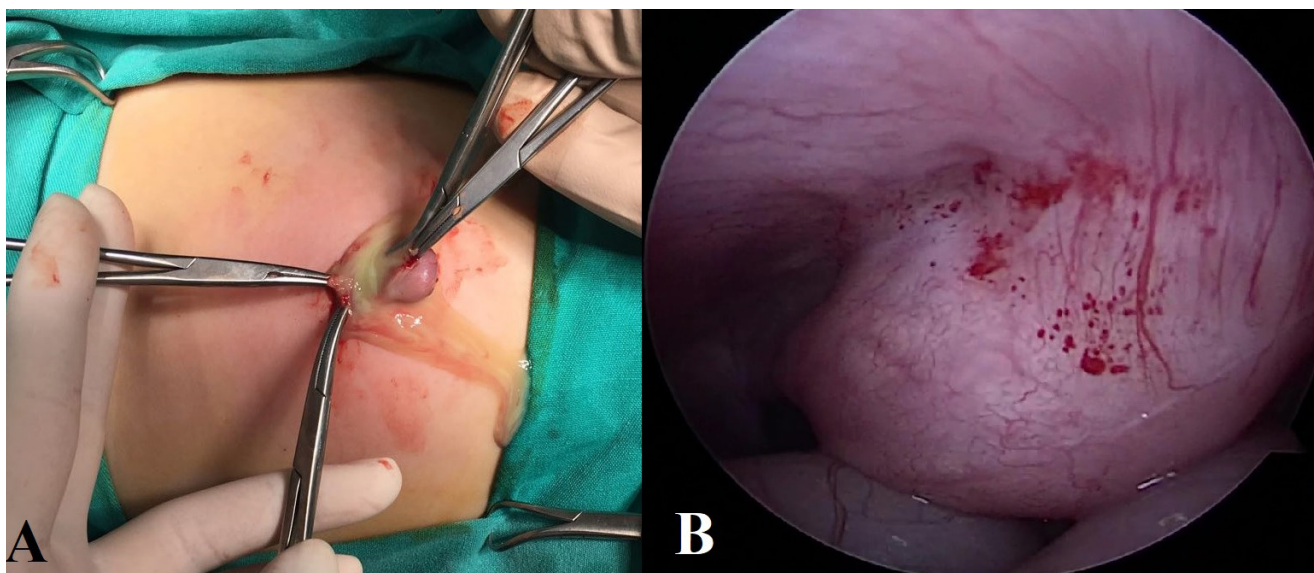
Discharge through the umbilicus in a patient who was referred as incarcerated umbilical herni depending on the ultrasonographic images (A). A 5 mm camera port was introduced through the Palmer's point and lack of peritoneal violation or contamination was confirmed by direct vision (B).
